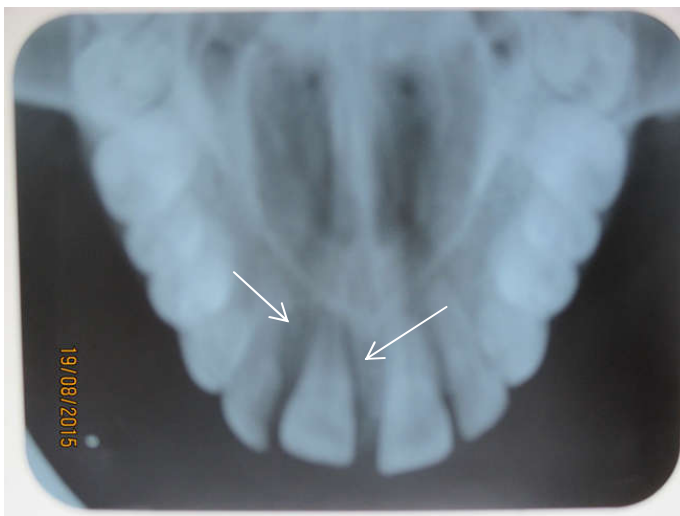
Maxillary anterior occlusal radiograph showing well defined unilocular radiolucency irt 11 and 12
